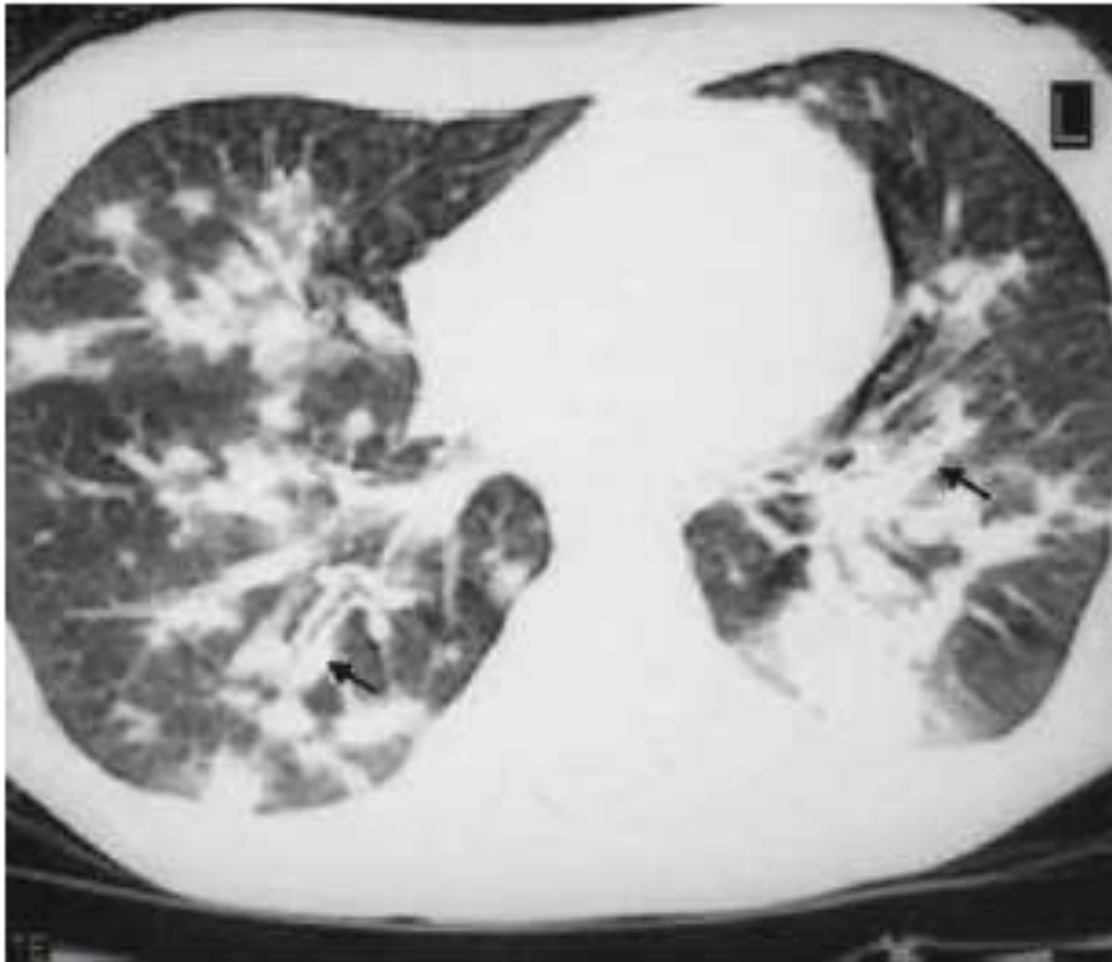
Kaposi Sarcoma with bilateral pleural effusion on CT scan: a) pulmonary window: peribronchial thickening and nodules on the right side. B) mediastinal window: calcified subcarinal and right hilar lymph node enlargement.
